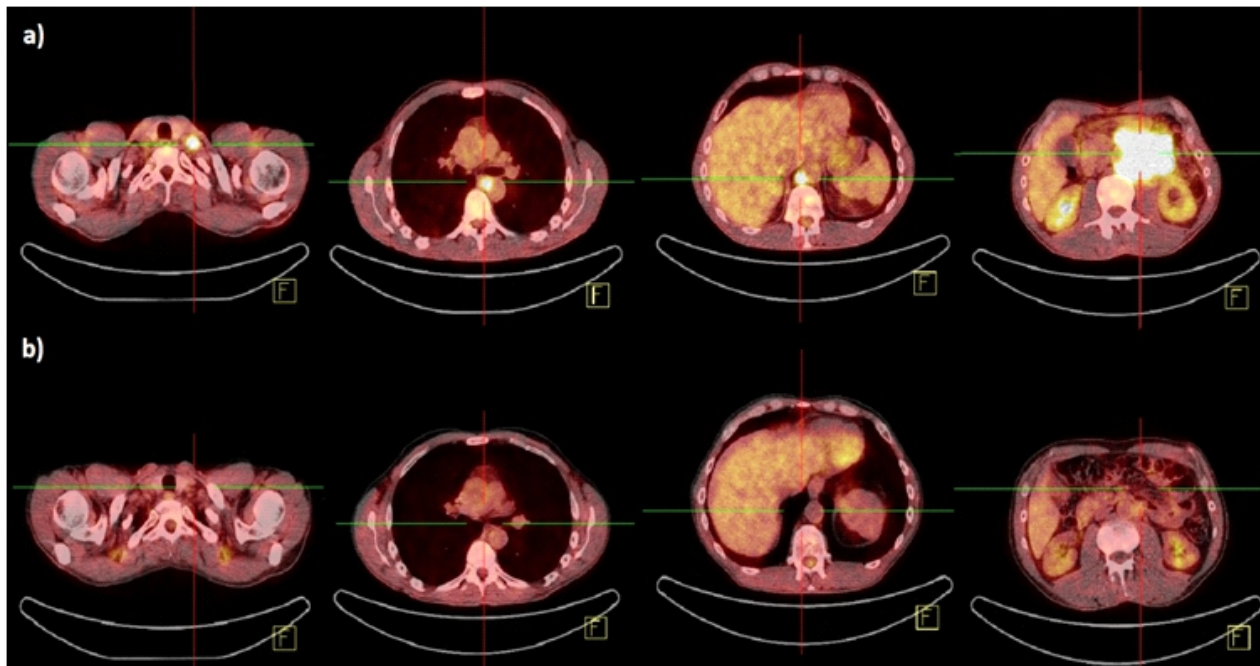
Transversal plane of ^{18}F -FDG PET/CT: a) Initial ^{18}F -FDG PET/CT shows disseminated disease in supraclavicular, mediastinal, retrocrural lymph nodes and left hemi-abdomen (SUVmax up to 13.4); b) Evaluation of therapy response on a control ^{18}F -FDG PET/CT showing regression.
